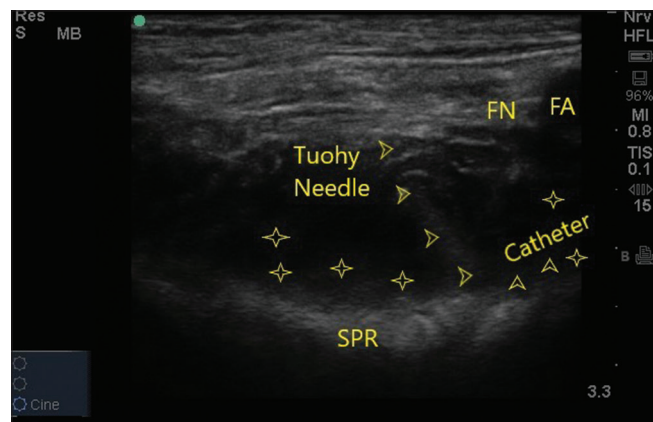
Out-of-plane PENG block sonographic image shows catheter insertion through Tuohy needle. *hydro-dissection with saline, FA-femoral artery, FN-femoral nerve, SPR-superior pubic ramus
